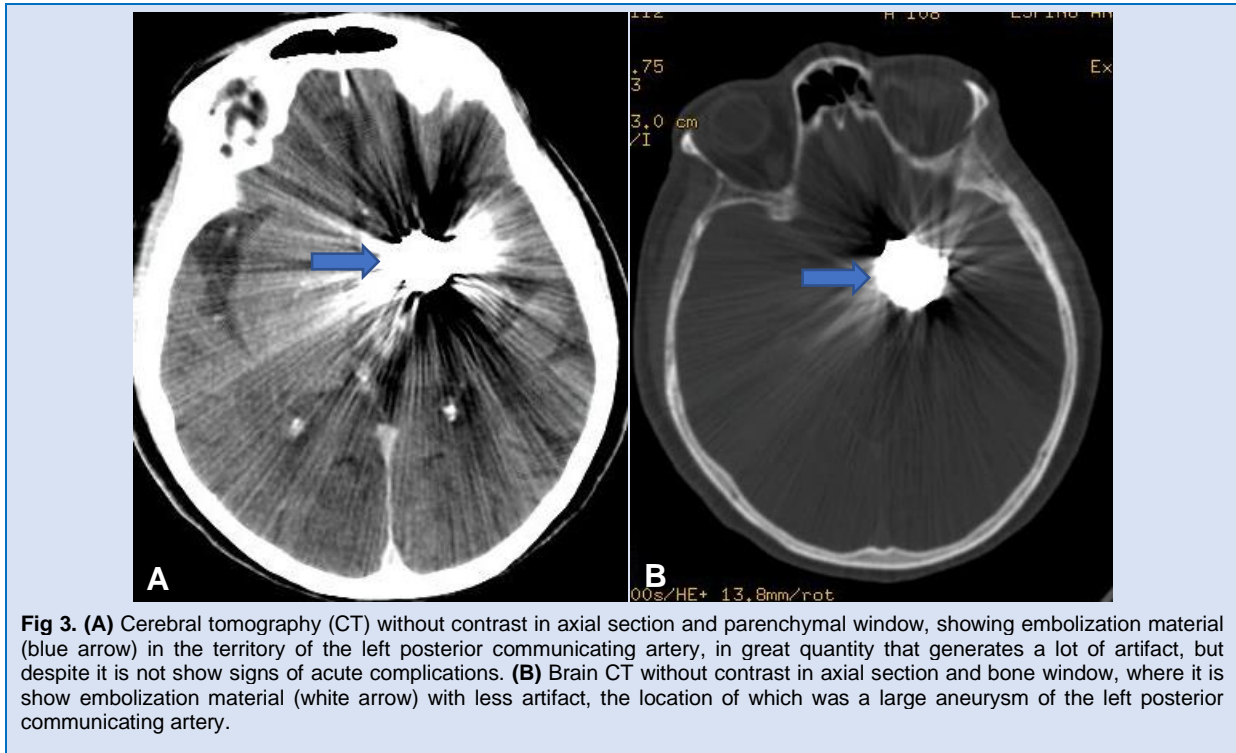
(A) Cerebral tomography (CT) without contrast in axial section and parenchymal window, showing embolization material (blue arrow) in the territory of the left posterior communicating artery, in great quantity that generates a lot of artifact, but despite it is not show signs of acute complications. (B) Brain CT without contrast in axial section and bone window, where it is show embolization material (white arrow) with less artifact, the location of which was a large aneurysm of the left posterior communicating artery.
